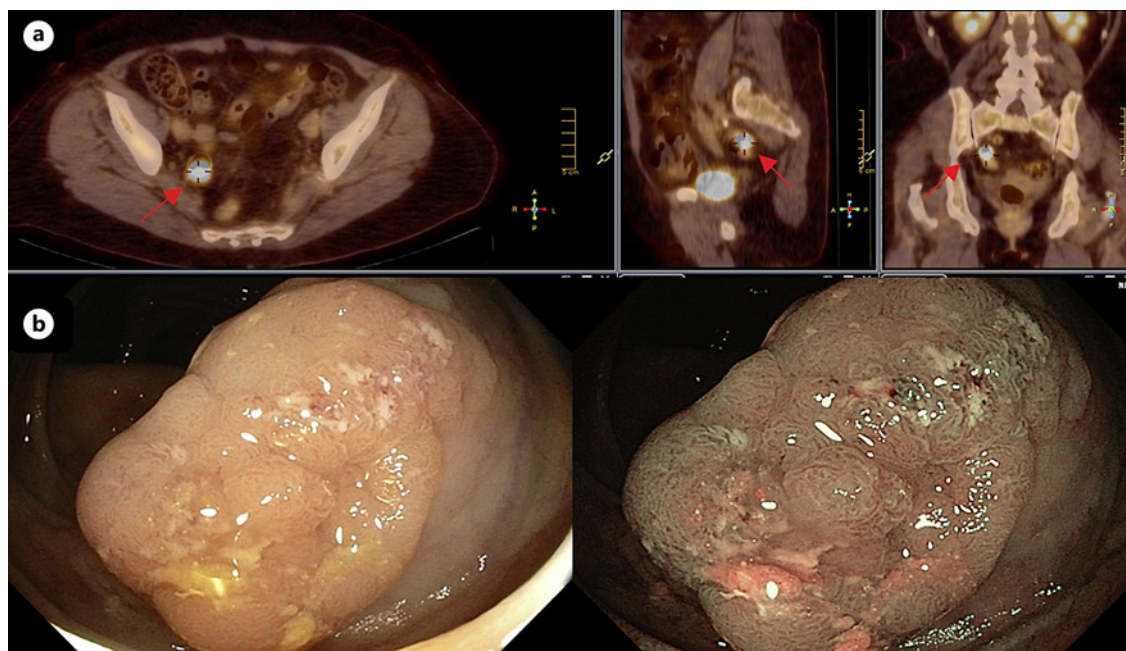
Sixty eight-year-old man was submitted to 18Fluorine-FDG PET/computer tomography in the context of a hematological disorder. There was incidental FDG uptake in the ascending colon. The patient underwent colonoscopy, which showed a tubulo-villous adenoma which harbors high-grade dysplasia. a Fused
